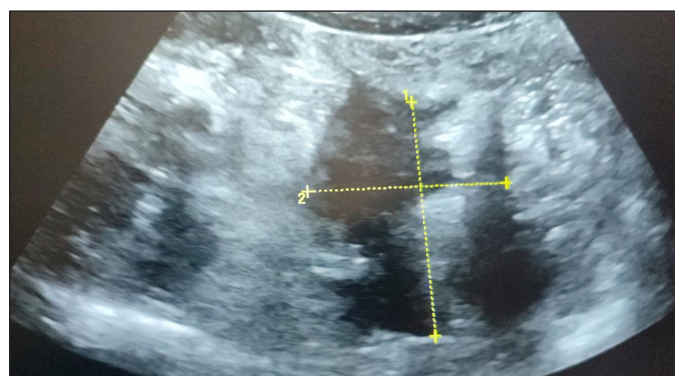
Crohn's disease. Interasal area, with poorly demarcated margins of about 3.9 x 4 cm with isoechoic and other anechoic areas that may be an inflammatory plastron without being able to rule out abscessation without performing ultrasound contrast.
